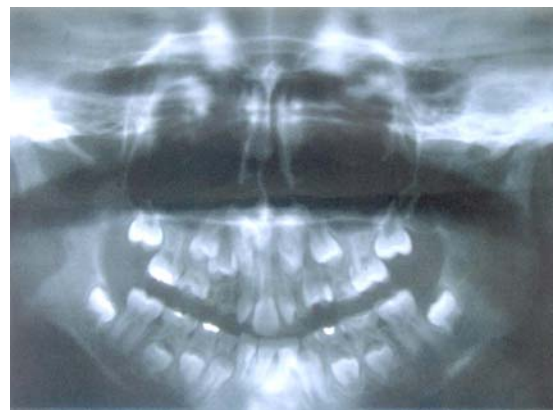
Orthopantomogram. Note the symmetrical single maxillary central incisor and the asymmetric septum deviated to the right.
